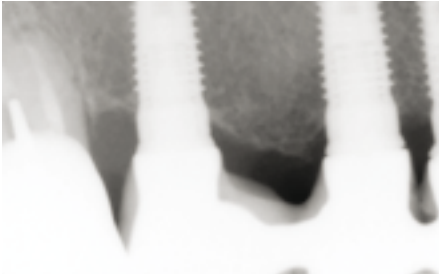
X-ray check of the bridge during the try-in: note the slight gaps in the mesial implants. They were due to a contact point with 13 that was too tight.
